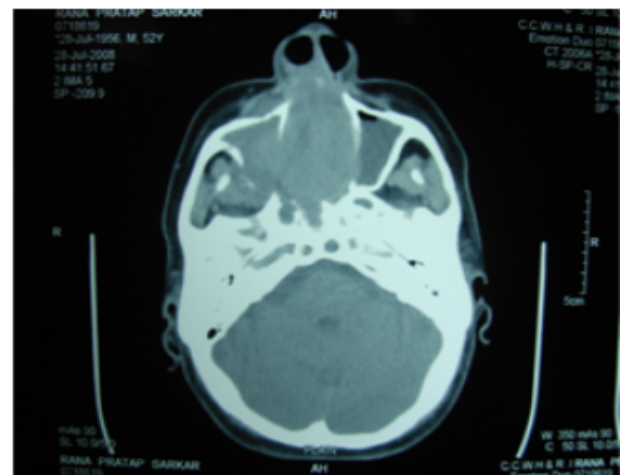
CT scan & MRI of patient no. 5
